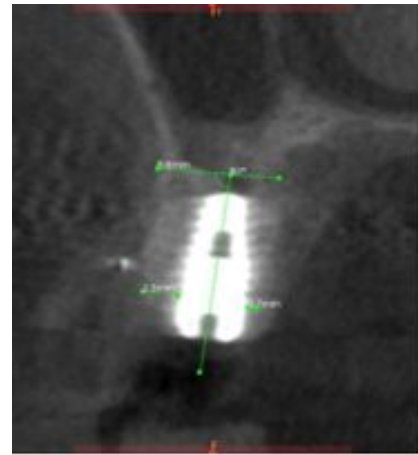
Post-operative evaluation of linear measurement of distance of the placed implant from the buccal and lingual cortices at the crestal level by software analysis of CBCT scan.
